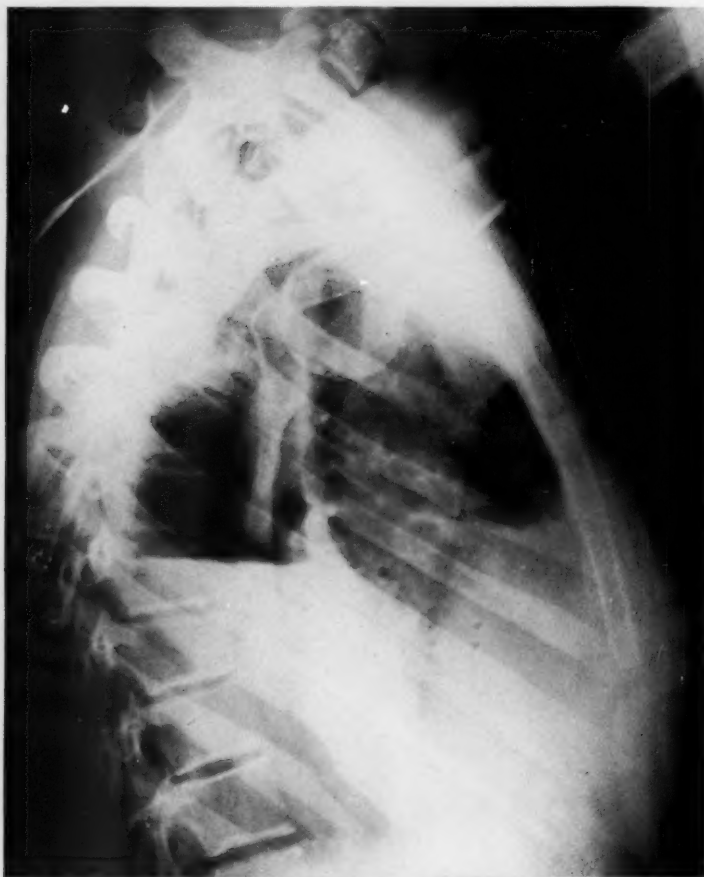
Case 12, Table II: Right lateral roentgenogram taken following aspiration of pus and injection of air before transfer to the Thoracic Service. Anterior and posterior fluid levels are clearly visible.
